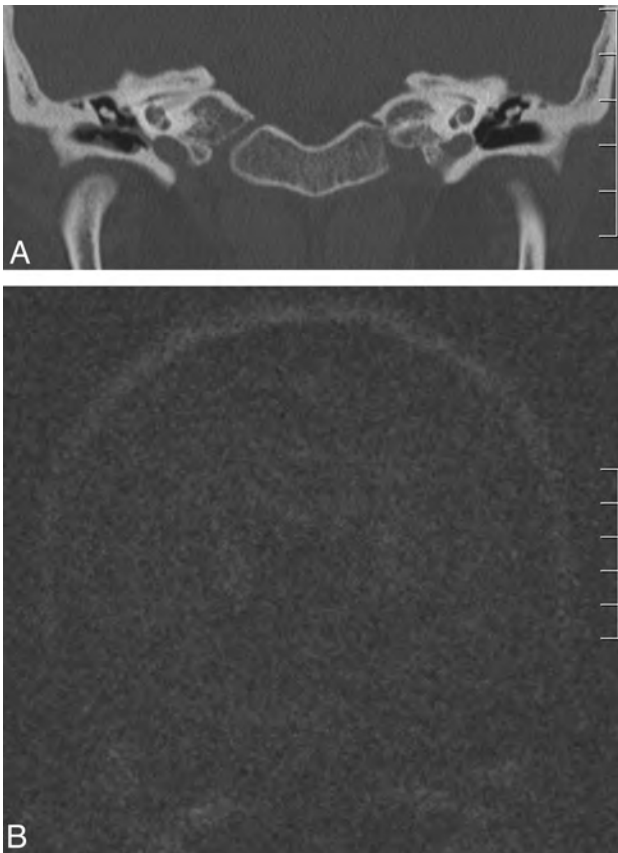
Case 3. A 39-year-old woman with no prior otologic diagnosis. A, Coronal CT scan shows right tympanic membrane thickening with occupation of Prussak space. B, Coronal HASTE shows no hyperintensity. In surgery, a granulomatous mass was identified without evidence of cholesteatoma (not shown).
